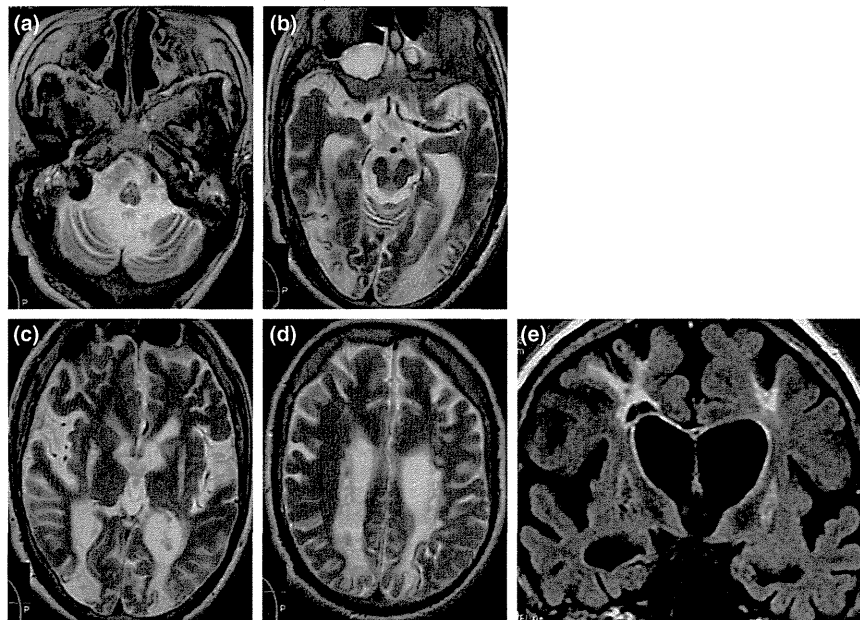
(a–d) T2-weighted images. (e) Fluid-attenuated inversion recovery image. T2-weighted magnetic resonance images show symmetrical high-signal intensity lesions in the (a) olivary nuclei, (c) putamen, and (b–d) cerebral cortex and white matter in the parieto-occipital lobes. (d, e) Some of the white matter lesions appear to be cyst-like.
